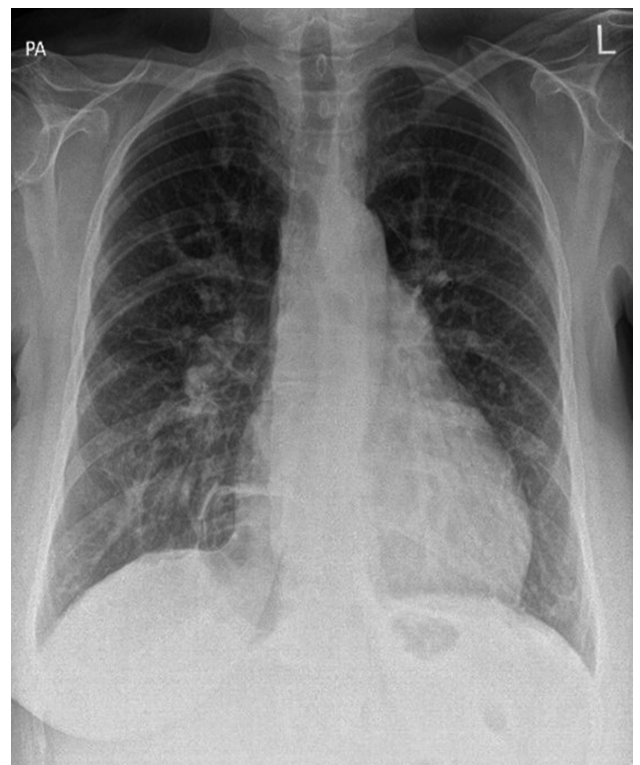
Initial chest X-ray from 2019.
